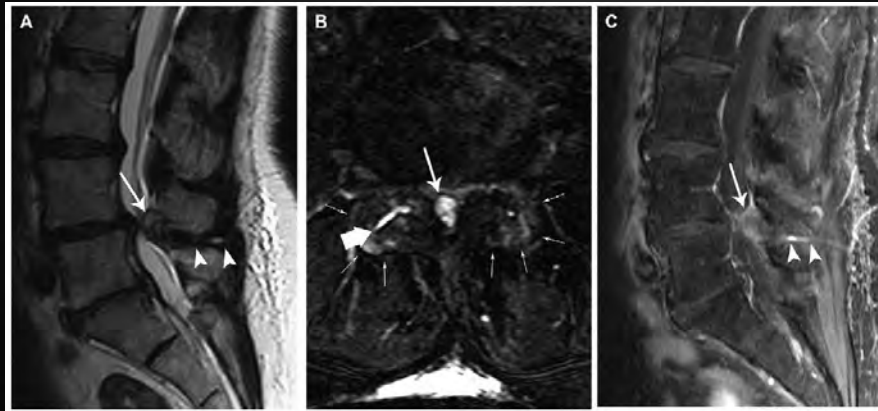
Interspinous bursitis and midline epidural cyst. A 59-year-old woman with a history of breast cancer presents with back pain radiating to left buttock exacerbated in the upright position. Sagittal FSE T2-weighted image (A) shows fluid in the interspinous space (arrowheads) tracking to a poorly visualized midline posterior epidural cyst (white arrows). Axial fat-suppressed FSE T2-weighted image (B) better demonstrates the midline posterior epidural cyst (arrow), concurrent bilateral facet synovitis (thick white arrow), and right facet joint effusion (small white arrows). Enhancement in the interspinous space (arrowheads) and at the periphery of the midline epidural cyst (arrow) is well seen on the sagittal fat-suppressed CE T1-weighted image (C).
